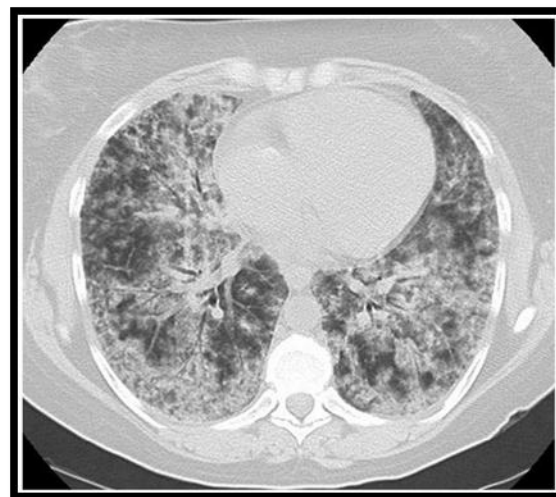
CT scan showing dense consolidation and dependent areas with ground glass attenuation.
